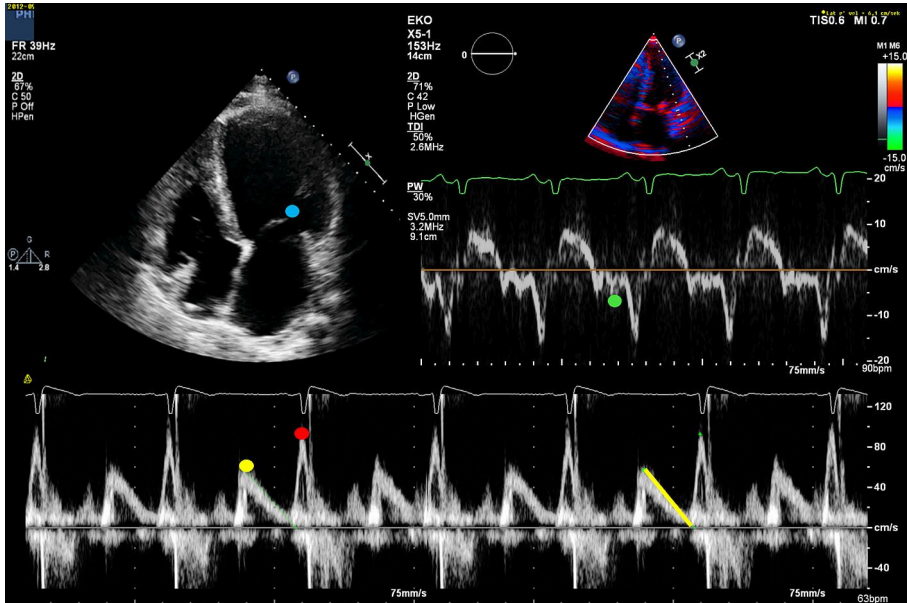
Measurements of echocardiographic parameters of diastolic function.
